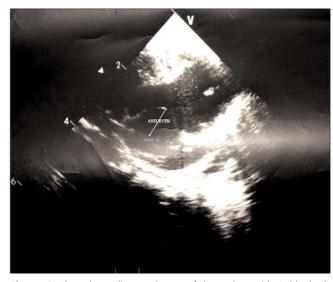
The echocardiogram image of the patient with Goldenhar's syndrome: The arrow show the left interatrial septal aneurysm
